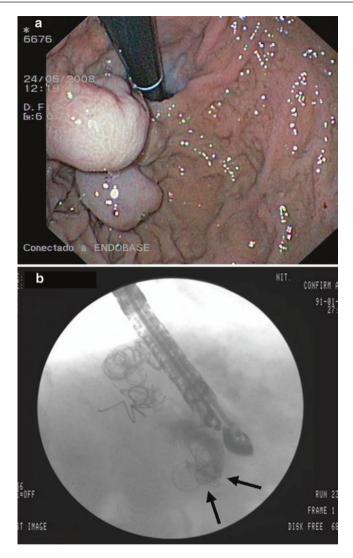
(a) Filling of the venous system can be seen using CO₂ in a percine model. (b) EUS-g coil embolization of gastric varices: radiographic view. Courtesy of Rafael Romero-Castro, Department of Gastroenterology, Virgen Macarena Hospital, Seville, Spain.
